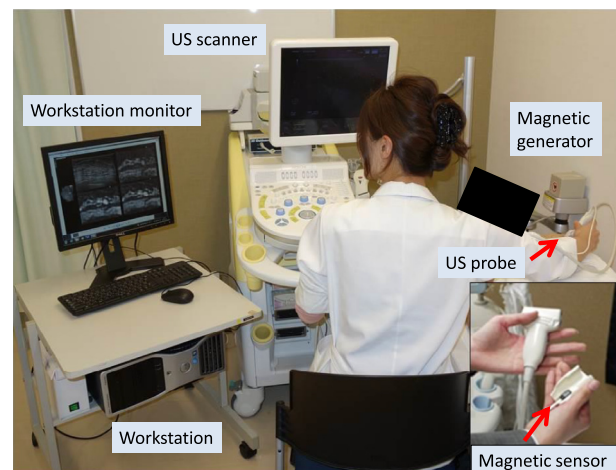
Equipment and operating technique for real-time virtual sonography system (prototype) in the outpatient consultation room. US = ultrasound.
